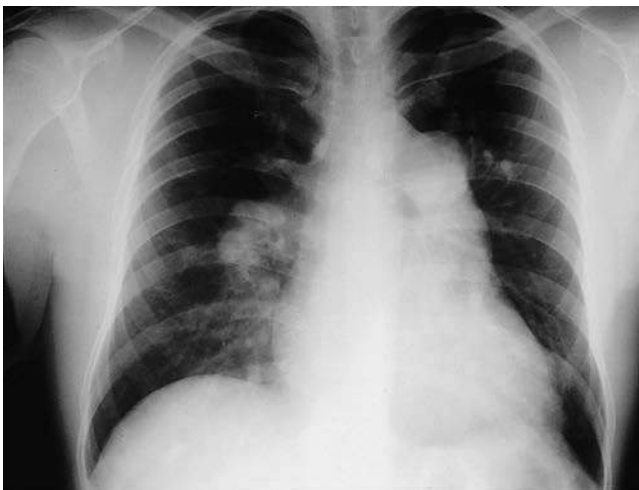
Chest radiograph of a patient with idiopathic pulmonary arterial hypertension. There is significant enlargement of the main pulmonary artery and of the hilar pulmonary vessels bilaterally. The peripheral parenchymal vascularity appears diminished.
